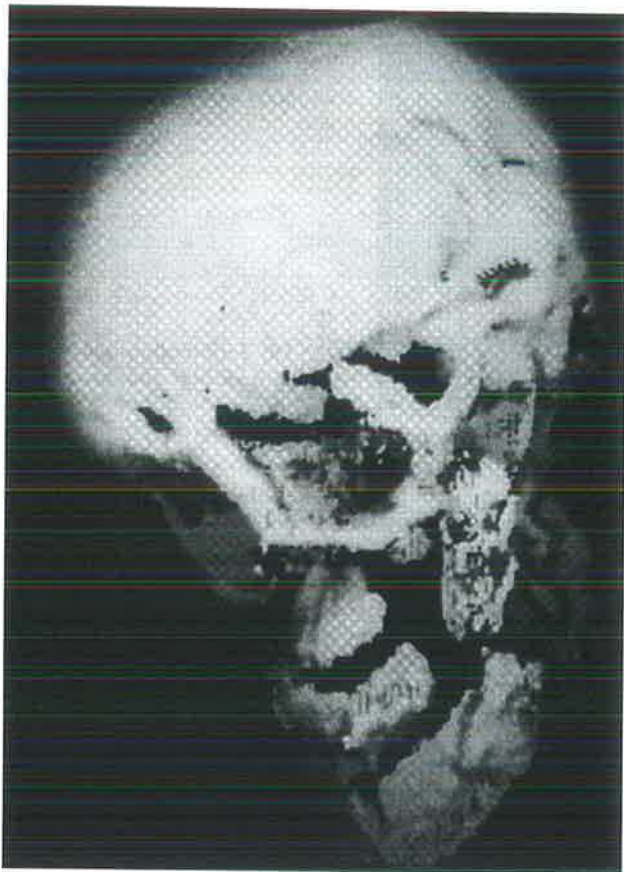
Post-operative 3D CT reconstruction showing the titanium implant*
